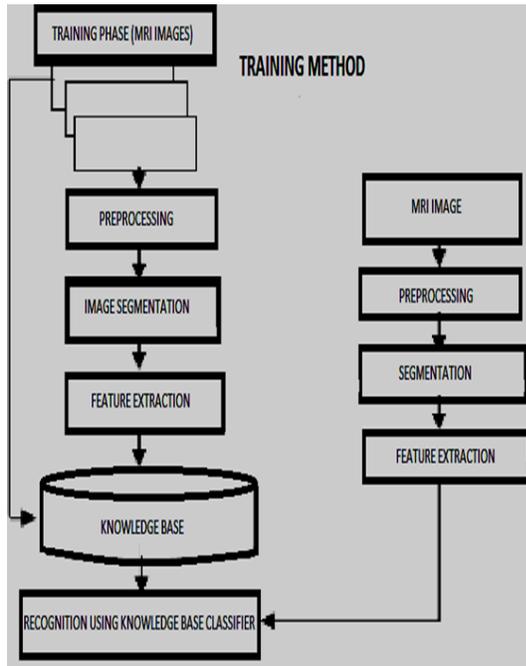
Proposed methodology for tumor detection in a brain MRI image
